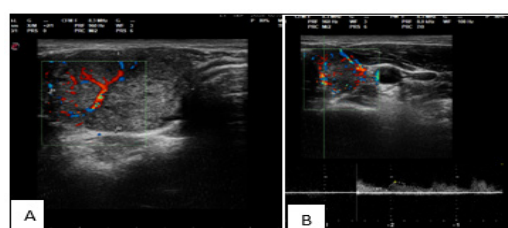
ATA Thyroid Nodule Sonographic Pattern - Low Suspicious. Pathological diagnosis - Adenomatous nodule - Bethesda - II.
